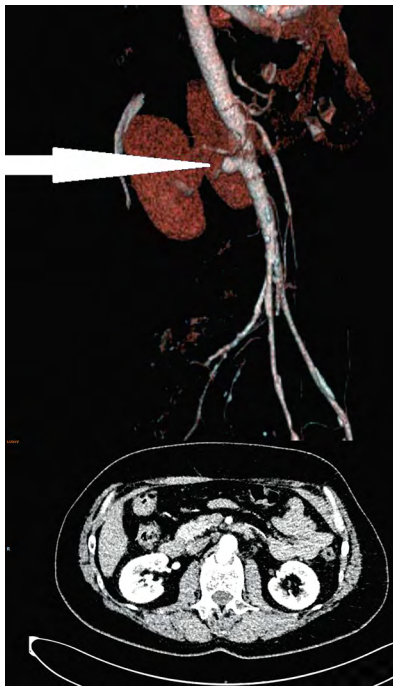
Computed tomography angiography confirming the diagnosis of penetrating aortic ulcer (white arrow).
